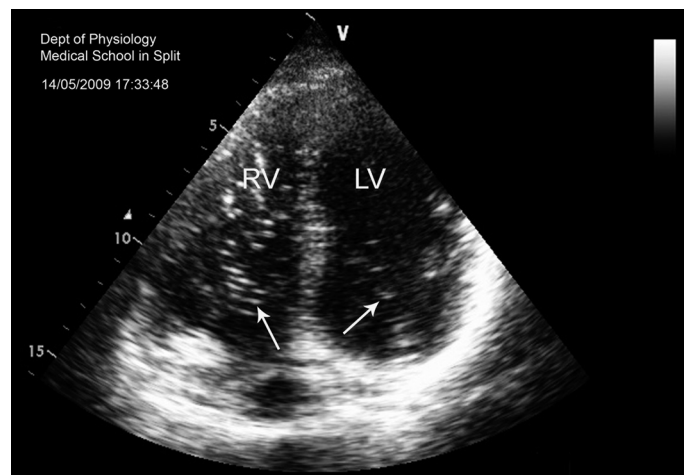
The presence of gas emboli in the heart after diving. Displayed is an echocardiographic apical 4-chamber view of the heart recorded at 45 min after *dive 1* in 1 of the test subjects. Gas emboli are seen both in the right and left cardiac cavities (arrows). RV, right ventricle; LV left ventricle.
